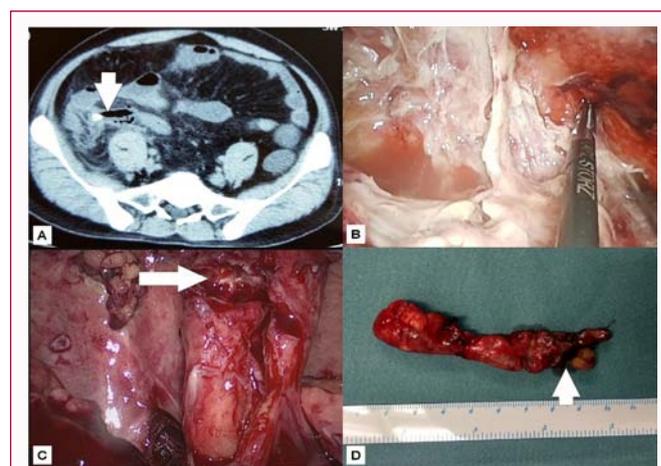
The clinical manifestation of this acute perforated appendicitis. A) The CT scan of acute perforated appendicitis. The arrow indicated the free abdominal gas (perforated location) and high density shadow (appendicolith). B) The intra-operative view of acute perforated appendicitis before appendectomy. Severe adhesions and pus masses were showed. C) The intra-operative view after cleaning abdominal pus and pus masses using laparoscopic gauze. The arrow indicated the perforated location. D) The appendix removed by laparoscopic surgery. The arrow indicated the perforated location and appendicolith.
